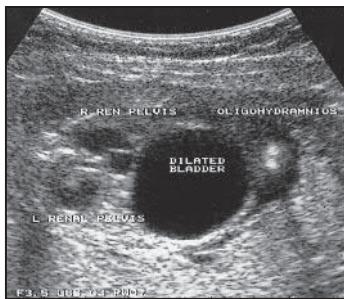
Antenatal ultrasound scan in an infant with urinary outflow obstruction from posterior urethral valve. (Courtesy of Karl Murphy.)
